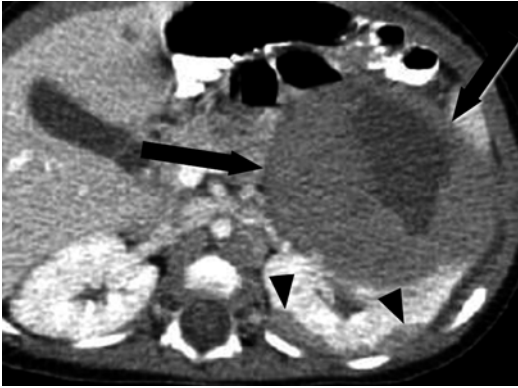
Left-sided Wilms tumor (*arrows*) and perilobar nephrogenic rests (*arrowheads*) on a transaxial section from a contrast-enhanced CT in a 6-month-old
